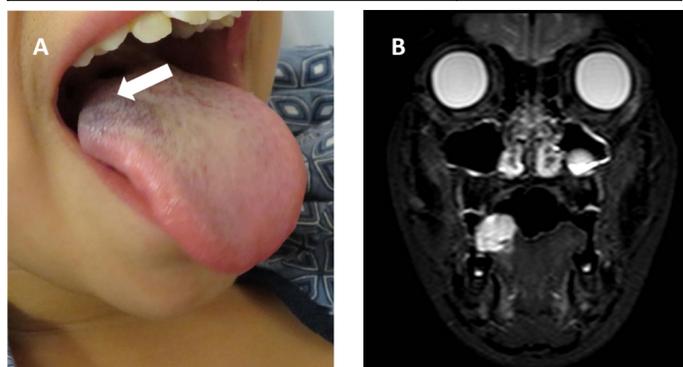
(a) Preoperative, post embolization of the tongue venous malformation (White arrow). (b) MRI, coronal, STIR image of the same lesion.
